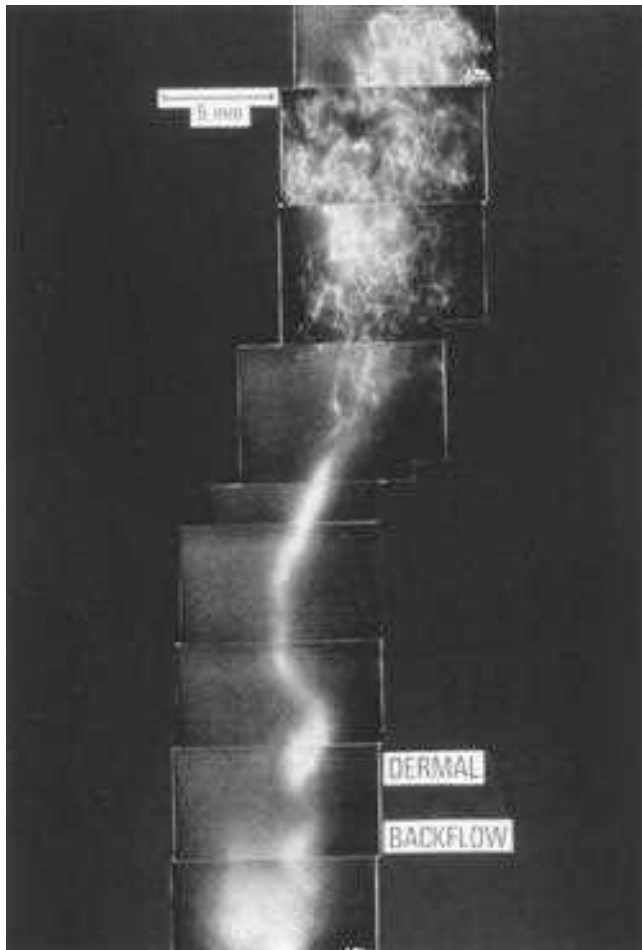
Lymphoscintigraphy of the lower extremity.
